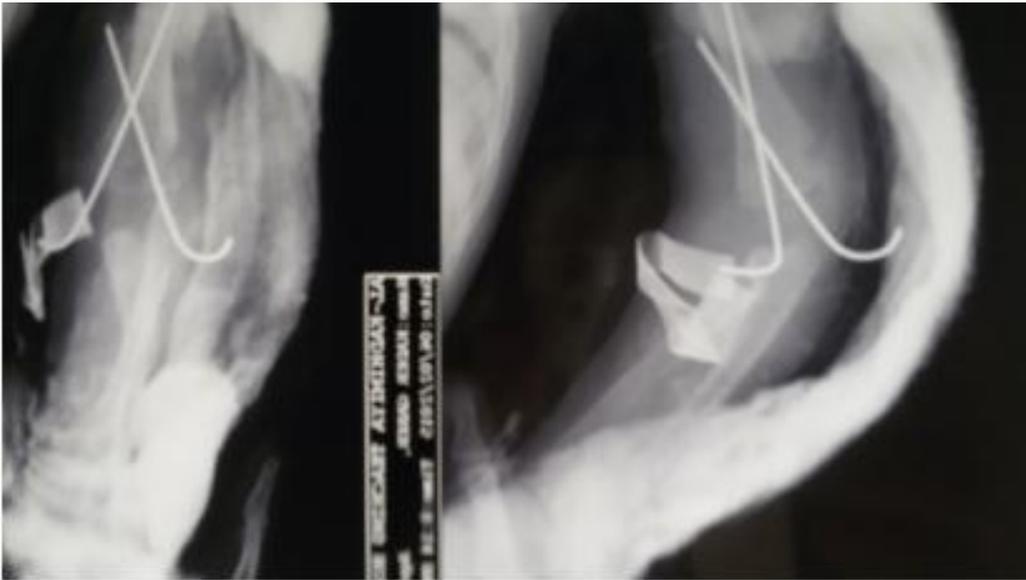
AP & Lateral x-rays of 3 years old patient treated with closed medial & lateral k wires
